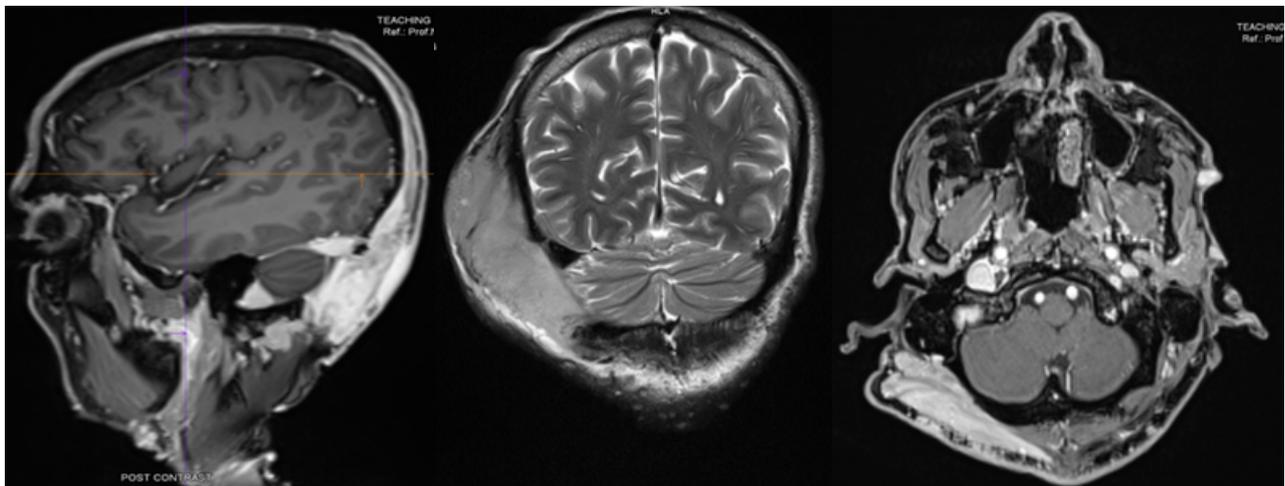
(A) MRI brain with contrast showing a large mass lesion seen in the subcutaneous tissue plane in the right occipital region
